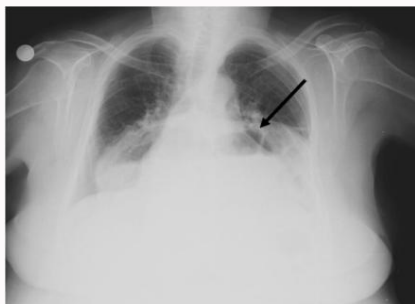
Preoperative chest X-ray. The arrow shows intra thoracic colonic gas.
